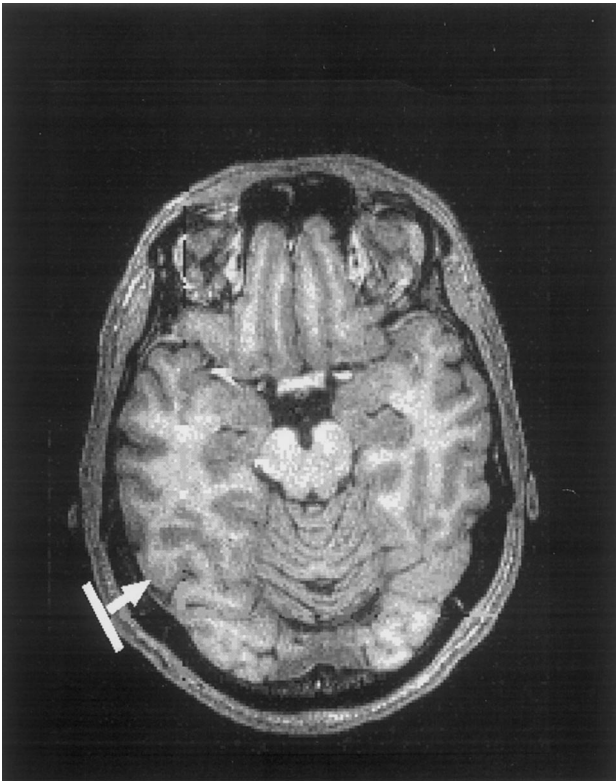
Structural MRI of subject JR. An axial slice is shown. The white bar represents the position and orientation of the stimulating coil; the arrow indicates that the closest point of contact between the coil and the cortex was the posterior aspect of BA37.
